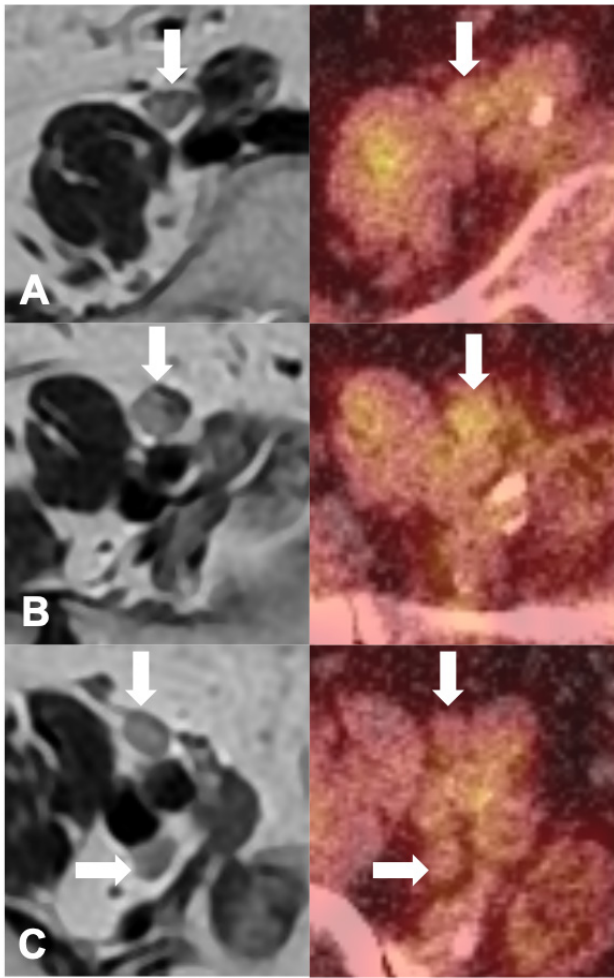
Post-operative repeat axial T2w and equivalent slice on FDG-PET/CT 8 months following initial presentation. There is development of multiple enlarged right sided common (1.2×0.8 cm in A) and external iliac (1.6×0.9 cm in B, 1.1×0.7 cm and 1×0.6 cm in C) lymph nodes (arrows) with low-grade uptake on the PET/CT.
